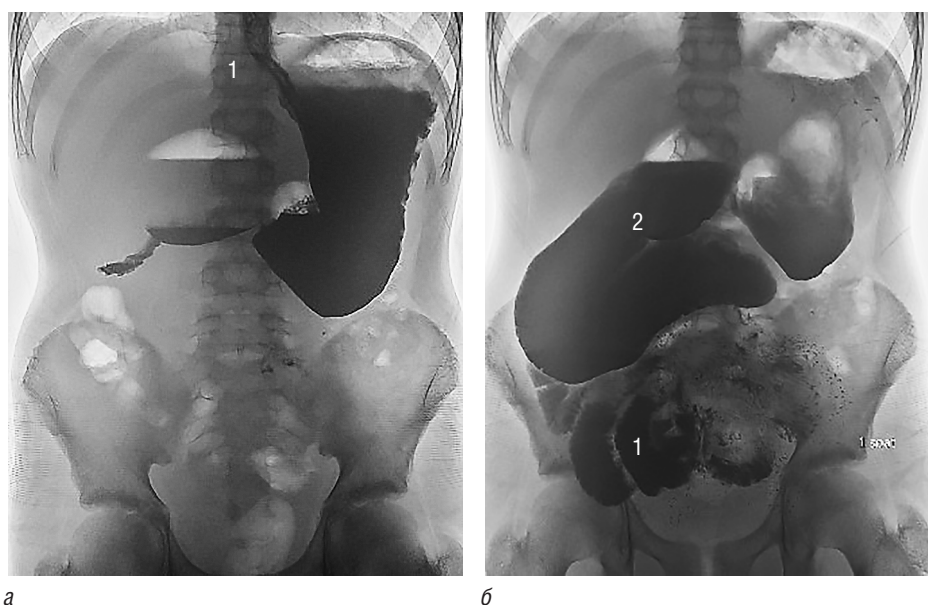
X-ray contrast study of the upper gastrointestinal tract with barium sulfate (a: 1 —gastroesophageal reflux; б: 1 — symptom of "spring"; 2 — megaduodenum)
